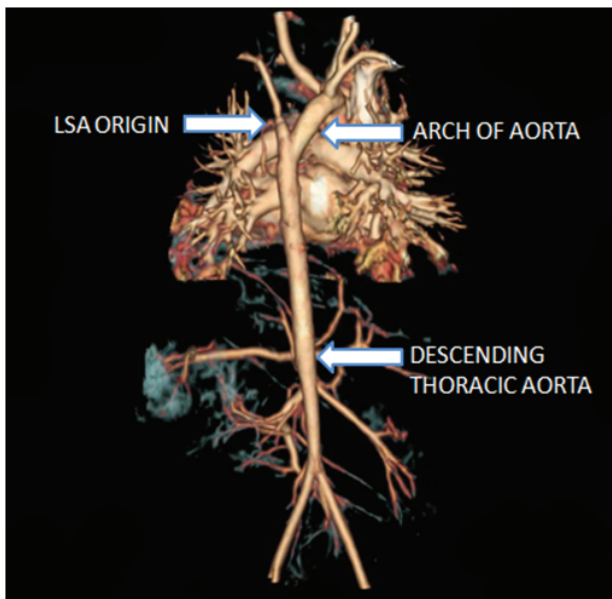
CT angiogram showing severe stenosis at LSA origin
